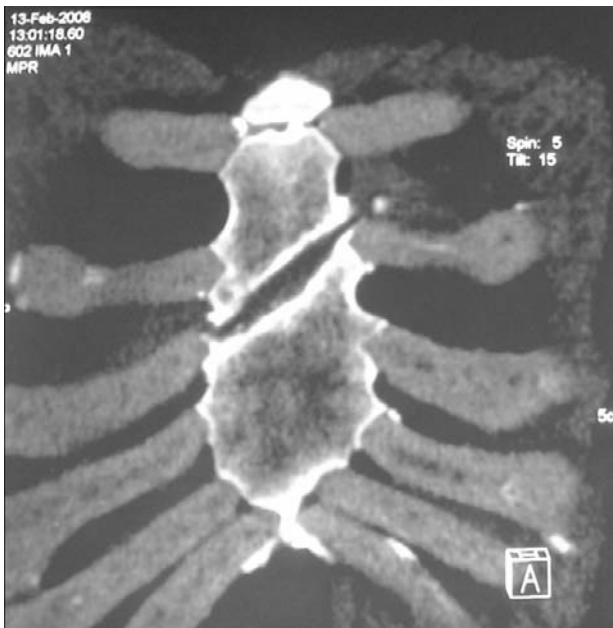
Displaced sternal fracture (CT scan).
